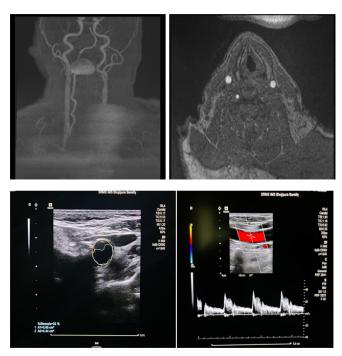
Case 4- MR angio neck vessels revealing focal short segment mild narrowing of left internal carotid artery almost 15 mm away from the bifurcation and hypoplastic left vertebral artery, USG doppler neck vessel reveals 32% stenosis of left inernal carotid artery however shows normal spectral doppler
